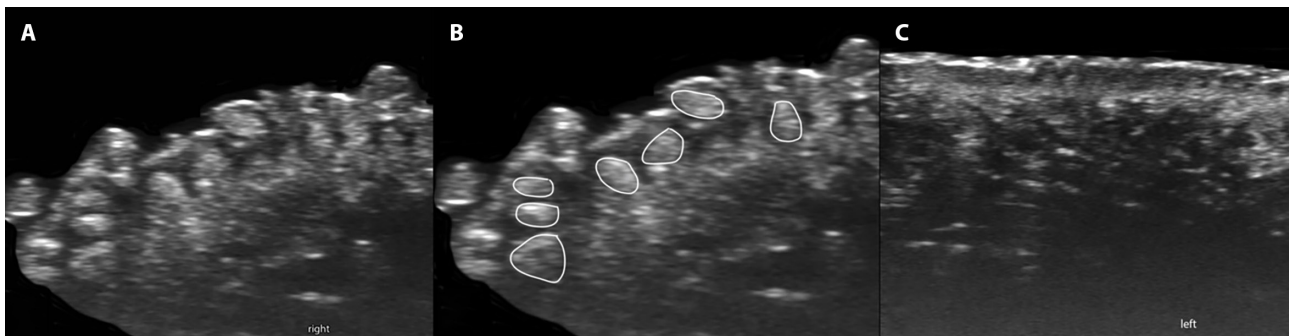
(A-C) Ultrasound at 70 MHz (Vevo MD; Visualsonics Fujifilm) of the tongue (transverse views) demonstrates multiple sebaceous glands as hyperechoic oval-shaped submucosal structures on the right side of the tongue (A) that were delineated with a white color (B). Notice the difference with the left side of the tongue (C) that does not present sebaceous glands.
